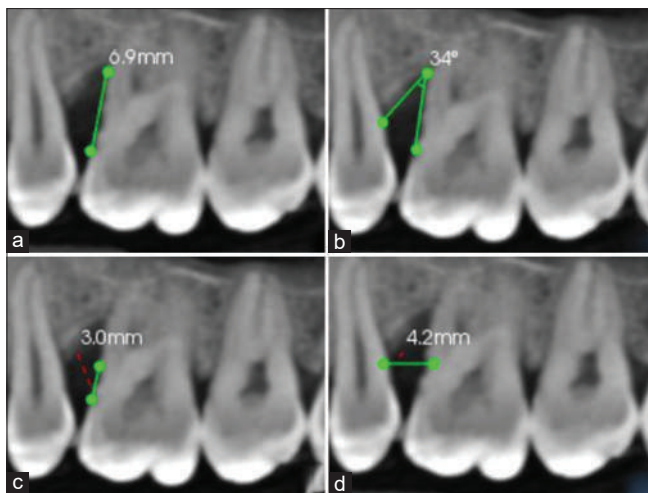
(a) Width of the defect on the mesial surface of 26 in cone-beam computed tomography; (b) Height of the defect on the mesial surface of 26 in cone-beam computed tomography; (c) Depth of the defect on the mesial surface of 26 in cone-beam computed tomography; (d) Defect angle on the mesial surface of 26 in cone-beam computed tomography
